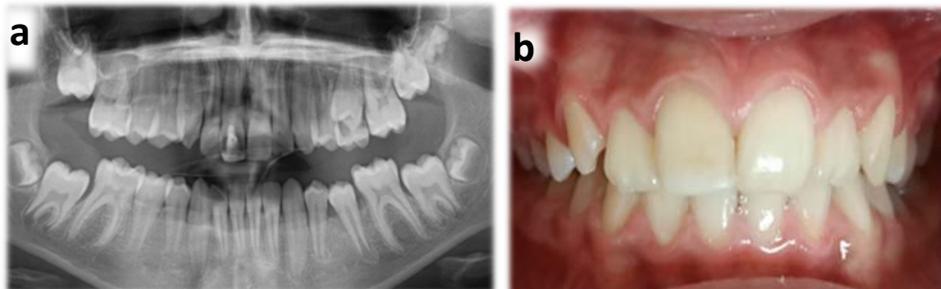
a: 3-year panoramic radiograph; b: 3-year intraoral photograph
